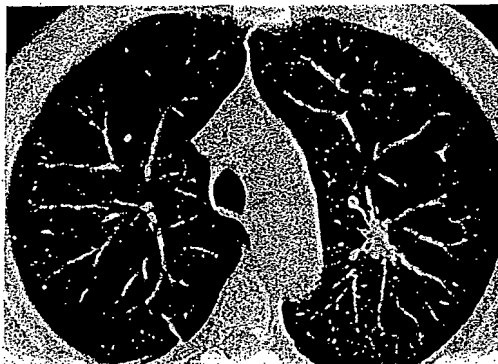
Seventy-one-year-old man with a spiculated nodule in upper left lobe demonstrated on low-dose helical CT (picture), but not visible on chest X-radiography. CT-guided biopsy showed adenocarcinoma.
